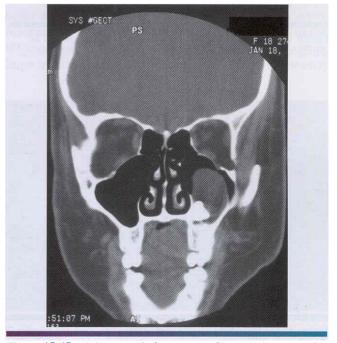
Odontogenic keratocyst. Computed tomography (CT) scan showing a large cyst involving the crown of an unerupted maxillary third molar. The cyst largely fills the maxillary sinus. (Courtesy of Dr. E.B. Bass.)
